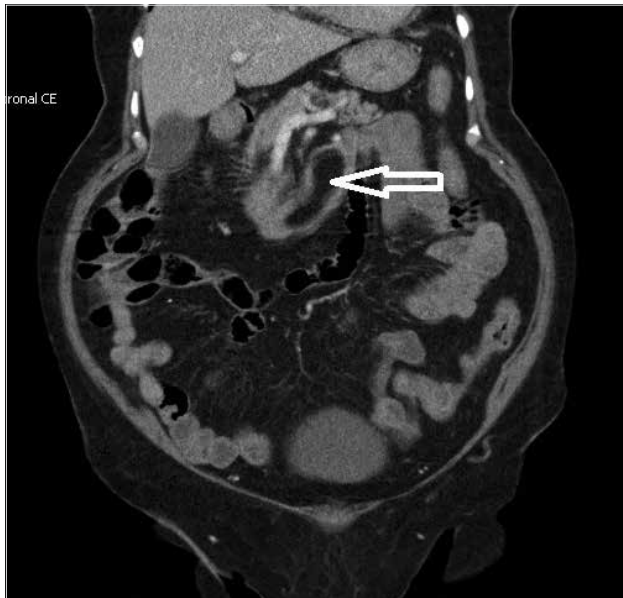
Computed tomography image on coronal section; duodenal lipoma (marked by arrow)
